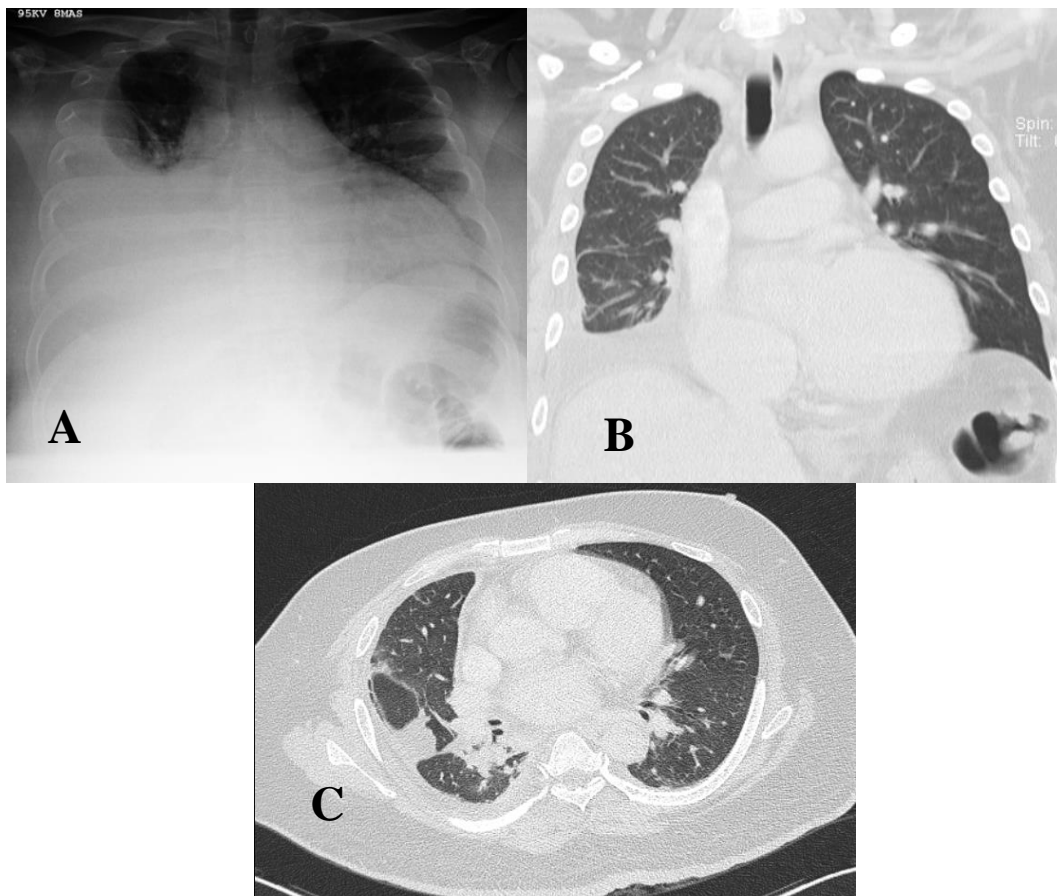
A) PA view chest radiograph showing right pleural effusion with enlarged cardiac silhouette. B) Coronal section CT scan thorax showing residual right pleural effusion with loculation in the right oblique and transverse fissures. C) Transverse section CT thorax showing collapse consolidation right perihilar region extending to the posterobasal and laterobasal segments.
